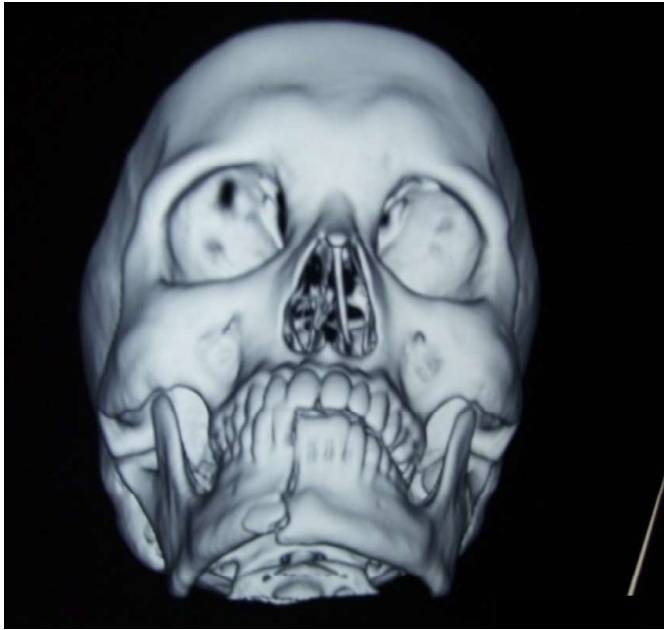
CT with 3D reconstruction showing symphysis fracture of mandible
